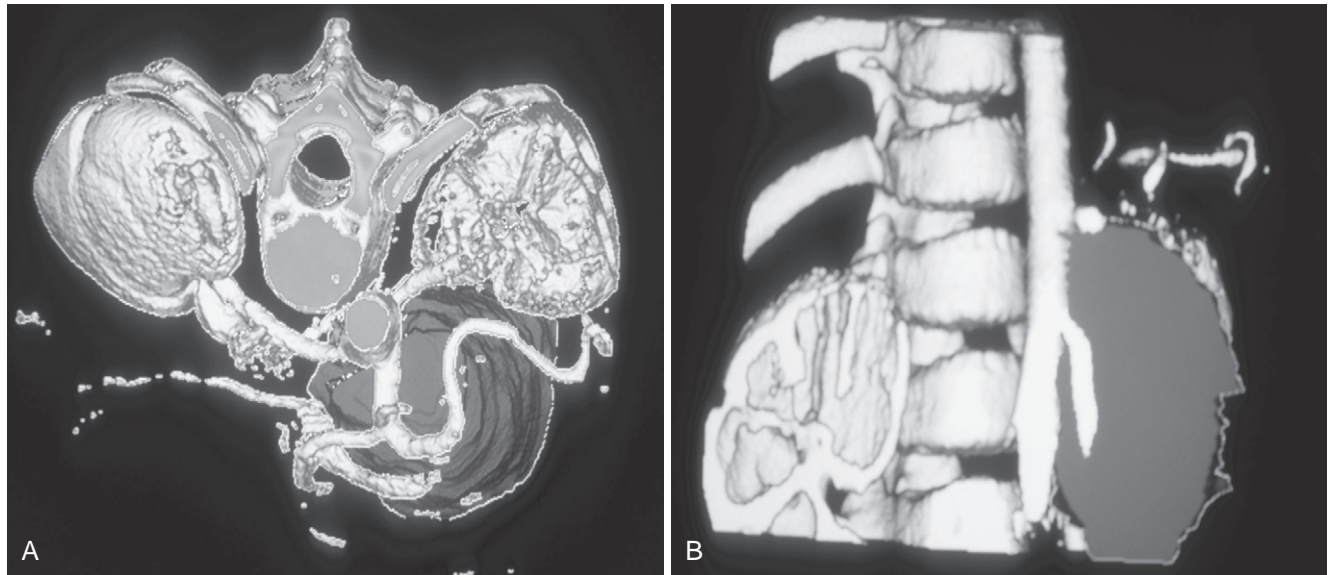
Helical computed tomography scan with three-dimensional reconstruction of a neuroblastoma arising near the celiac axis. A, Anterior view indicates that the tumor does not involve the branches of the celiac axis. B, Lateral view demonstrates that the superior mesenteric artery passes through the tumor.
